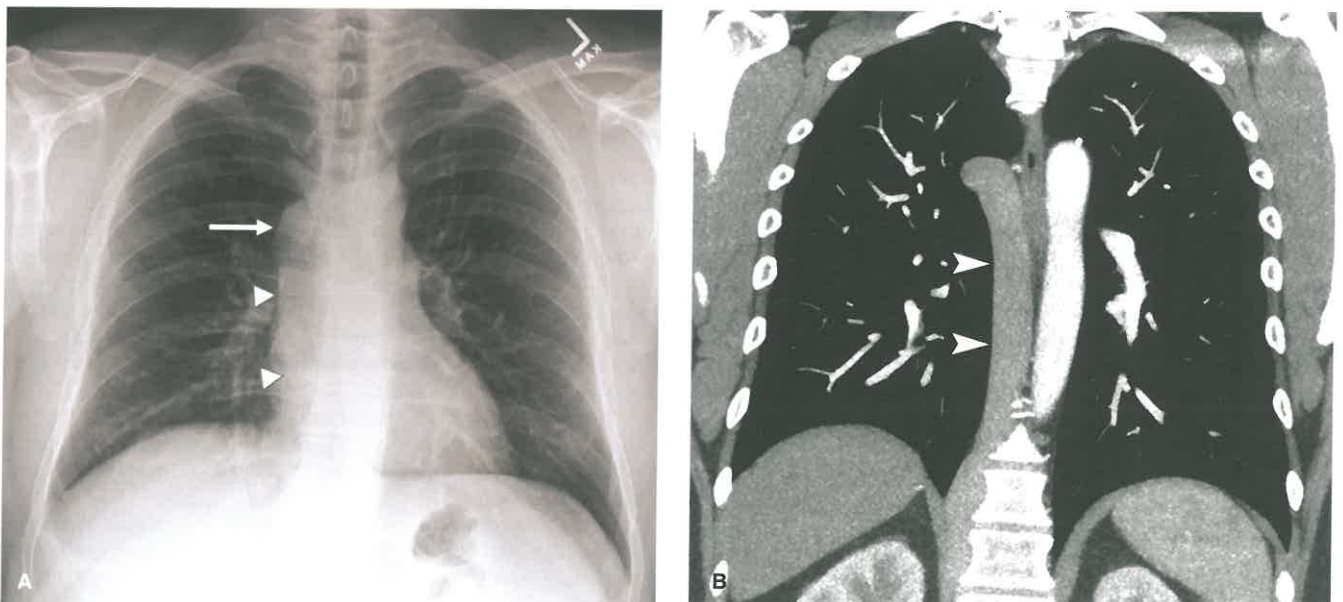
Azygos Continuation of the Inferior Vena Cava (IVC) as Right Paratracheal Mass. A: Frontal chest radiograph in an asymptomatic 40-year-old man demonstrates a right paratracheal mass (arrow), contiguous with a vertically oriented tubular opacity (arrowheads). B: Coronal contrast-enhanced CT shows a dilated azygos vein (arrowheads). The intrahepatic IVC (not shown) was absent; no other anomalies were identified.
